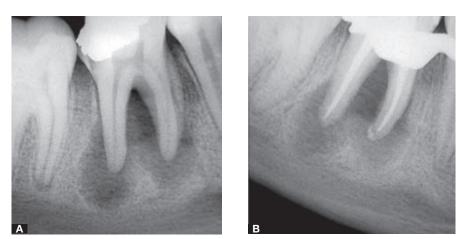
A) Diagnostic radiograph. B) Radiograph after root canal filling.
